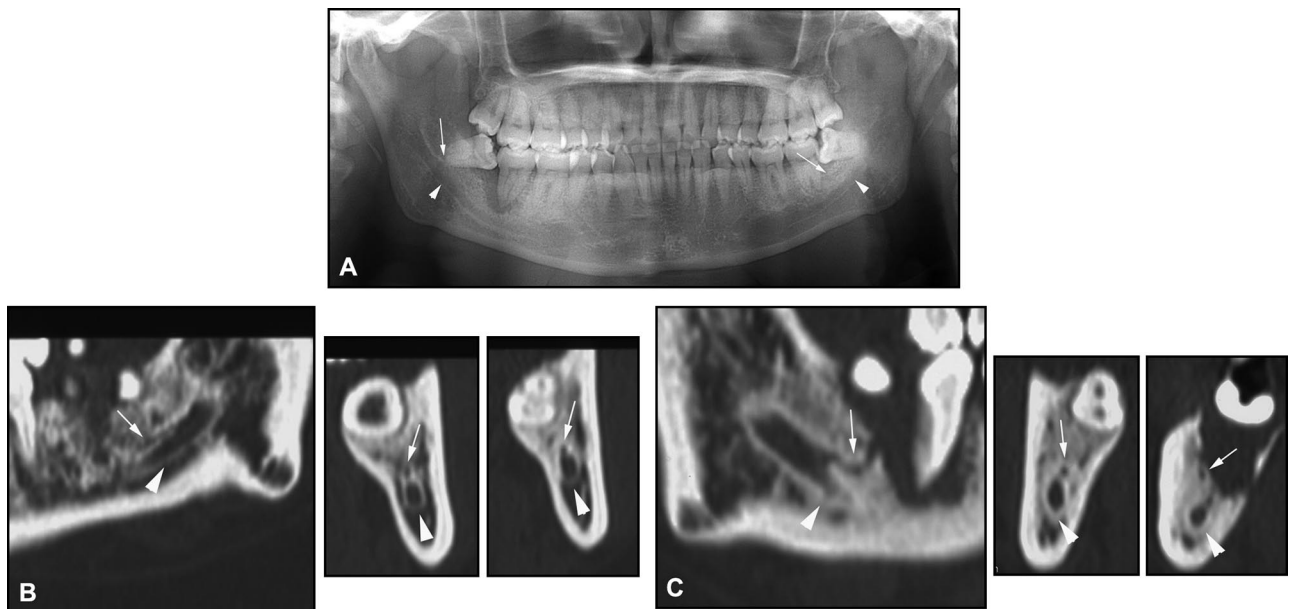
Radiographs of patient 2. A, Panoramic image. B, Reconstructed CT images in left side. C, Reconstructed CT images in right side. The left bifid mandibular canal was suggested, and the right mandibular canal slightly expanded in the root apex of the third molar on the panoramic image. In the left mandible, there was a single mandibular foramen and bifurcation of the mandibular canal in the third molar on the reconstructed CT images. The upper canal ran along the mandibular canal. In the right mandible, there was a single mandibular foramen and bifurcation of the mandibular canal in the third molar on the reconstructed CT images.
